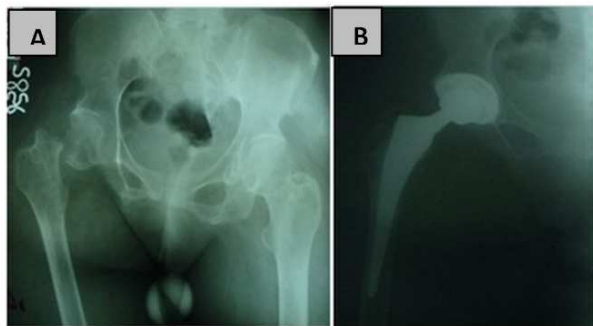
A 55-year-old woman with pseudarthrosis of the right femoral neck B X-ray after THA with non-cemented components.
